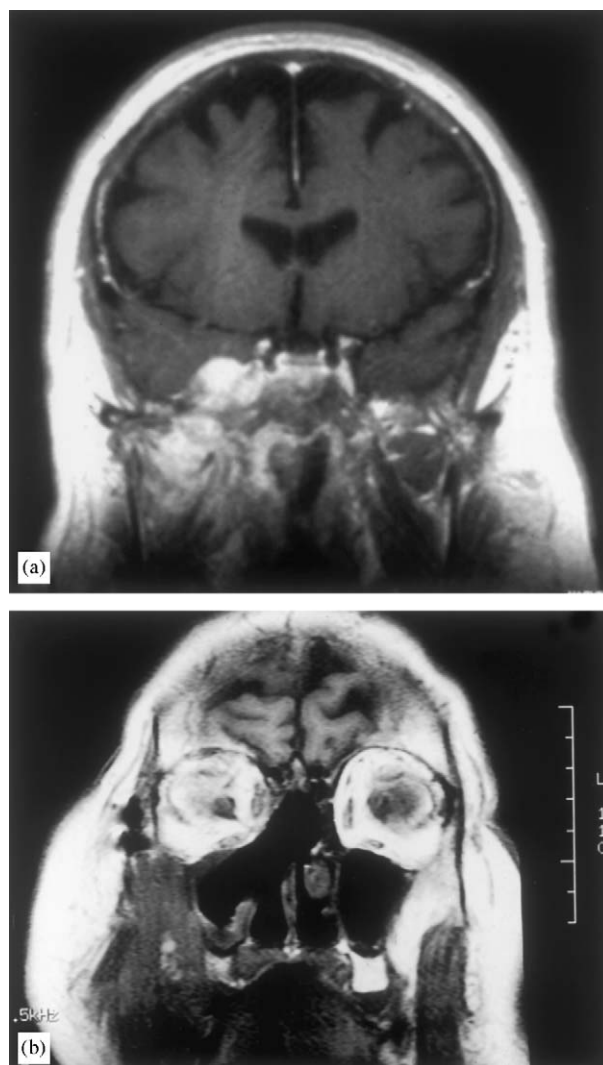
(a) Preoperative coronal MRI of a patient (62 years old) with an adenoid cystic carcinoma in the region of nasopharynx and paranasal sinuses. (b) Same, postoperative coronal MRI scan showing absence of tumour and a defect of naso-orbito-ethmoidal complex.
